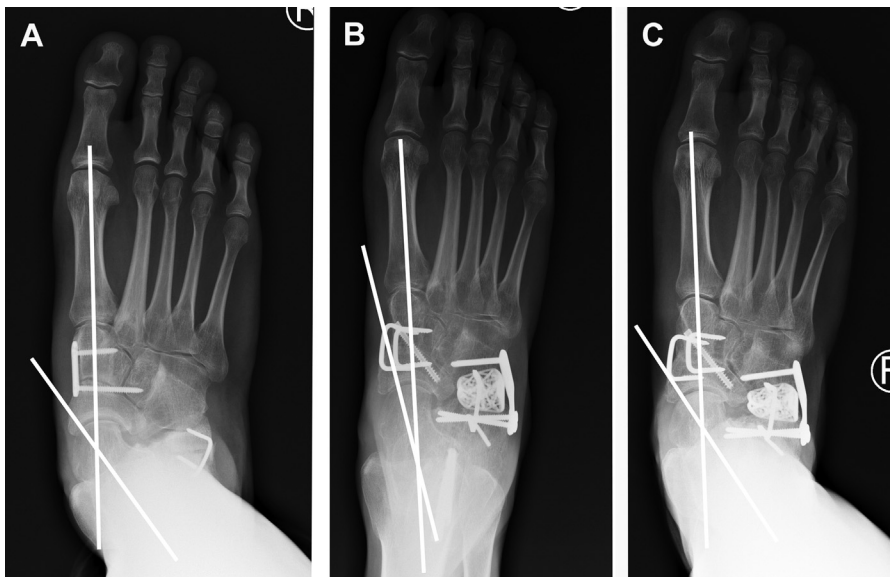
AP radiograph (A) of a patient who presented with a failed NC fusion and LCL. At 3 months (B), excellent correction was thought to be achieved following a revision NC fusion, LCL (calcaneocuboid (CC) fusion was required because of prior joint violation), MDCO, FDL transfer, and gastrocnemius recession. However, at 1 year, near-complete recurrence of the deformity (C) was noted with collapse through the TN joint.
